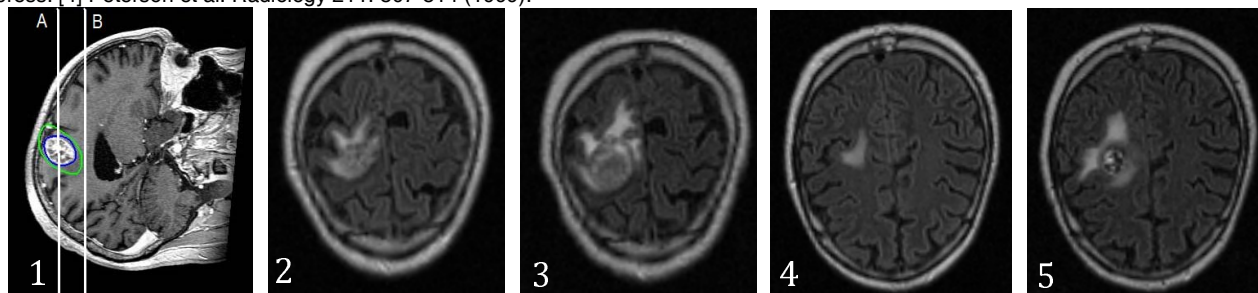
Planned dose (blue and green contours) and markers for axial slices A and B. Fig.2: Flair MRI, slice A, pre SRS. Fig.3: Flair MRI, slice A, 30 days post SRS. Fig.4: Flair MRI, slice B, pre SRS. Fig.5: Flair MRI, slice B, 30 days post SRS.
